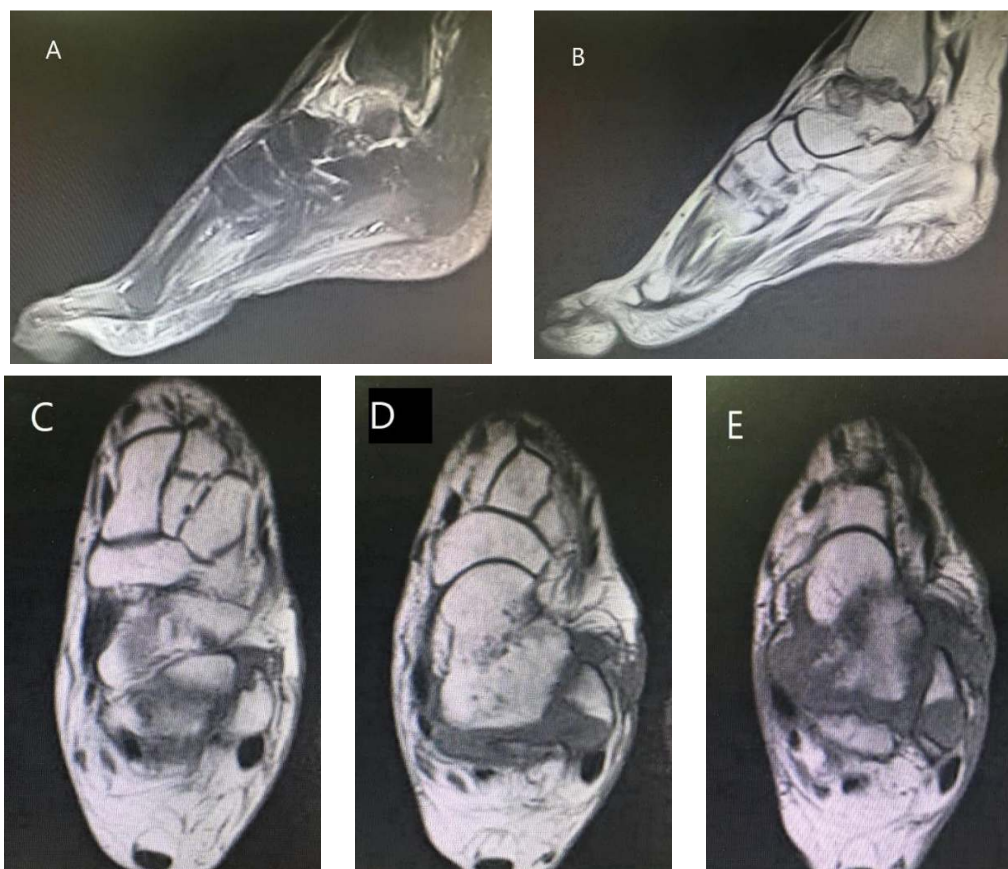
MRI of left foot and ankle. (A, B, C, D, E) bone marrow signal changes in talus, tibia plafond and lateral malleolus and also destructive changes is seen in the tibiotalar joint and lateral malleolus
